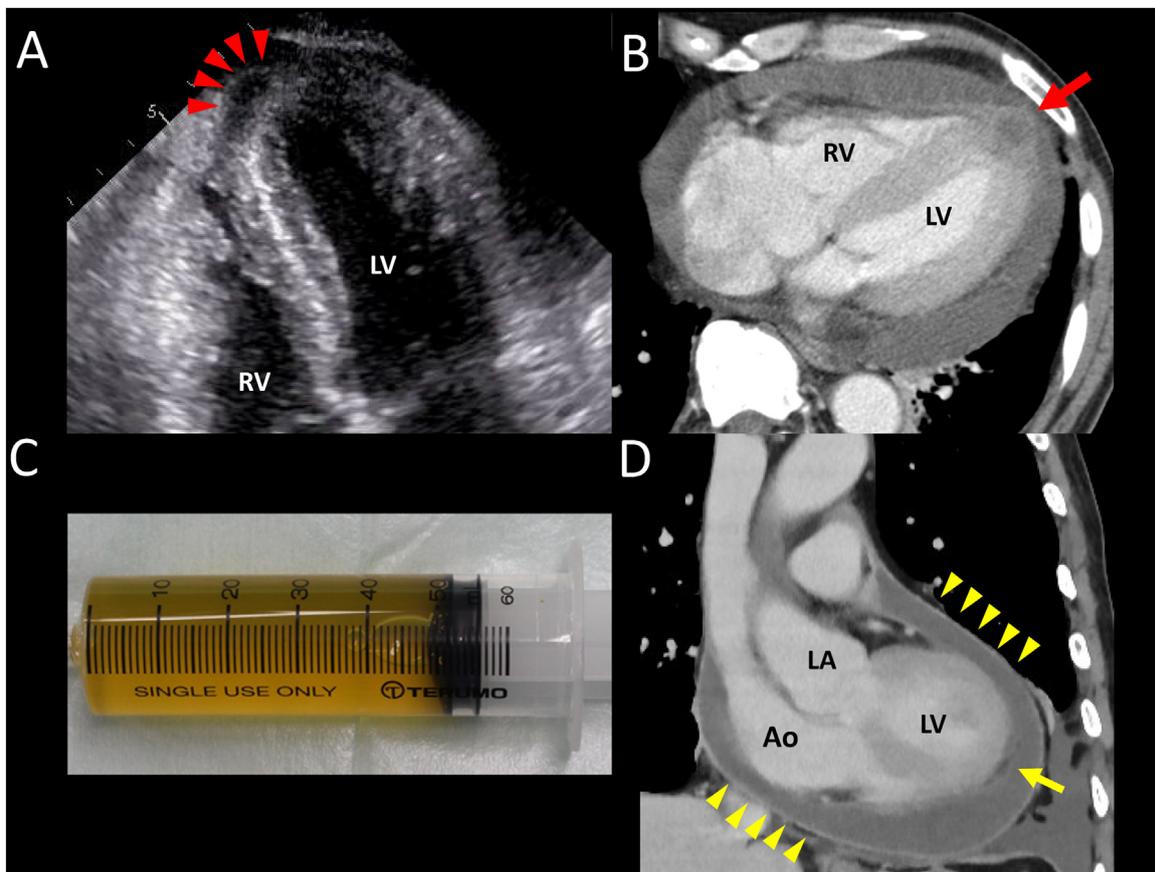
(A) Transthoracic echocardiography shows a large amount of pericardial effusion and a 20.5 × 19.5 mm low echoic tissue adjacent to the left ventricle (red arrowheads). (B) Contrast-enhanced CT on admission shows pericardial effusion and a roughly 20 × 20 mm abnormal mass between the left ventricle apex and pericardium (red arrow). (C) The appearance of pericardial fluid shows serosanguinous. (D) Contrast-enhanced CT on the 9th hospital day shows thickened pericardium (yellow arrowheads) and a roughly abnormal mass (yellow arrow). CT, computed tomography; LV, left ventricular; RV, right ventricular; Ao, aorta.
